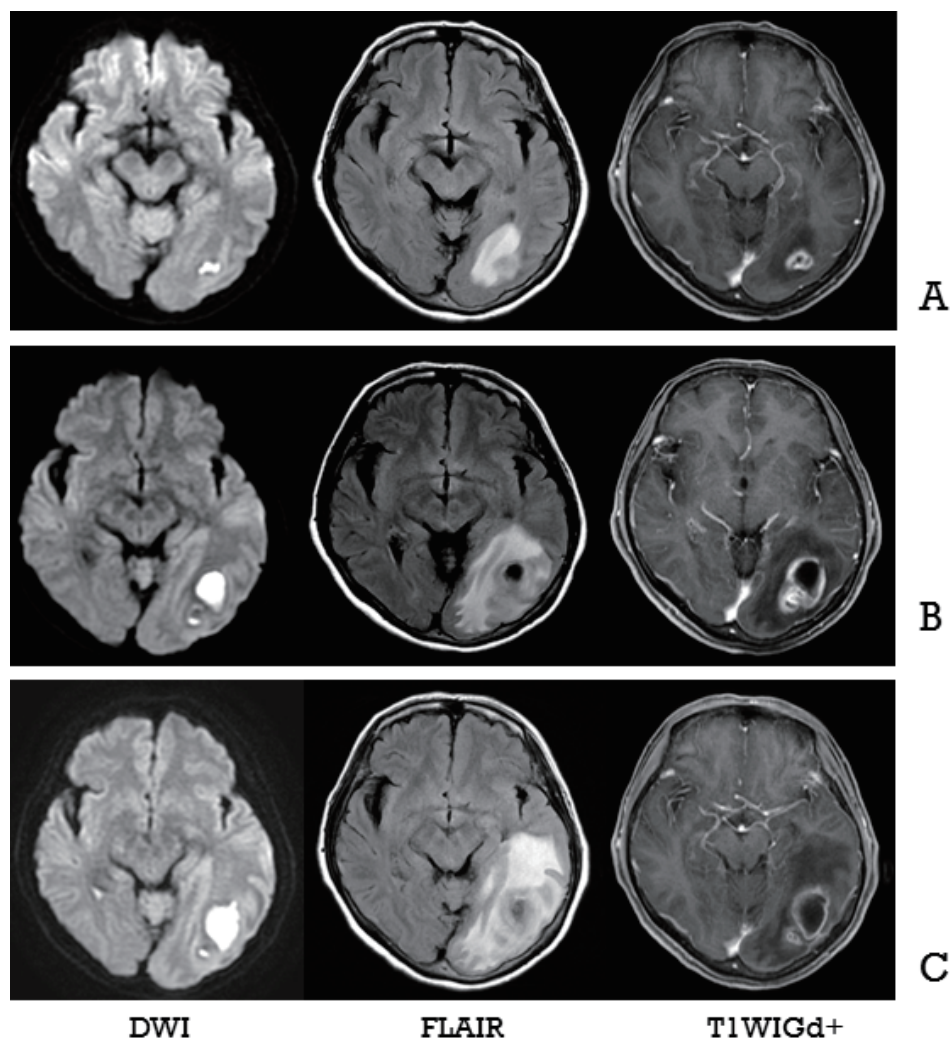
MRI (Axial) of the head shows temporal changes in lesions in the left occipital lobe. A) Hospitalization date B) 8th day C) 17th day (before drainage). High signal with DWI in the left occipital lobe, ring enhancement effect with Gd-T1WI. The high signal is widening in FLAIR images reminiscent of edema.
